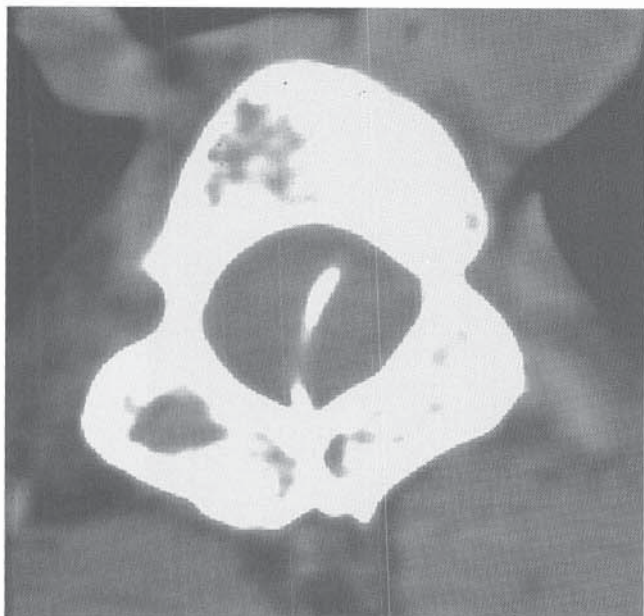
CT scan of a patient with diastematomyelia.
